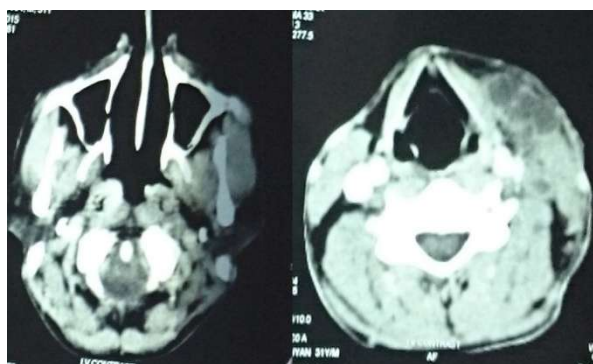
CT scan shows asymmetric soft tissue thickening involving the posterolateral aspects with effacement of fossa of Rosenmüller with bilateral multiple partially necrotic nodes
